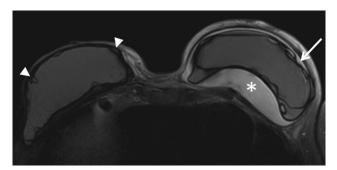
Axial T2 weighted fat-suppressed MRI sequence shows partially collapsed shell of the left breast implant (white arrow) surrounded by reactive fluid of high signal intensity (asterisk) and subcapsular hypointense wavy line of the right breast implant (arrowheads) without collapse of the shell, indicative of bilateral breast implant rupture.
